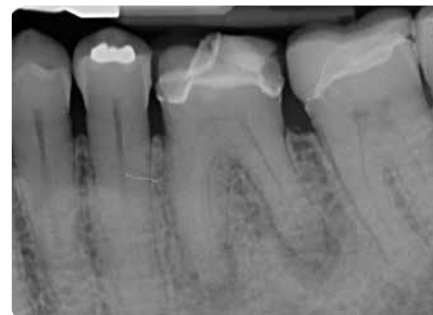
Note the destruction involved in producing this elective ceramic crown resulting in pulpal necrosis and periapical periodontitis of the lower left first molar tooth
